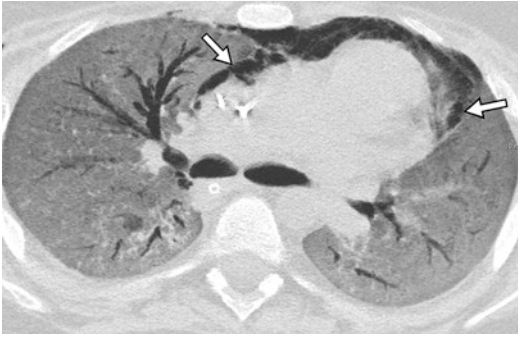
Air-leak syndrome in a 15-year-old boy with myelodysplastic syndrome and severe distress syndrome. CT scan shows diffuse ground-glass opacities associated with spontaneous pneumomediastinum (arrows)
